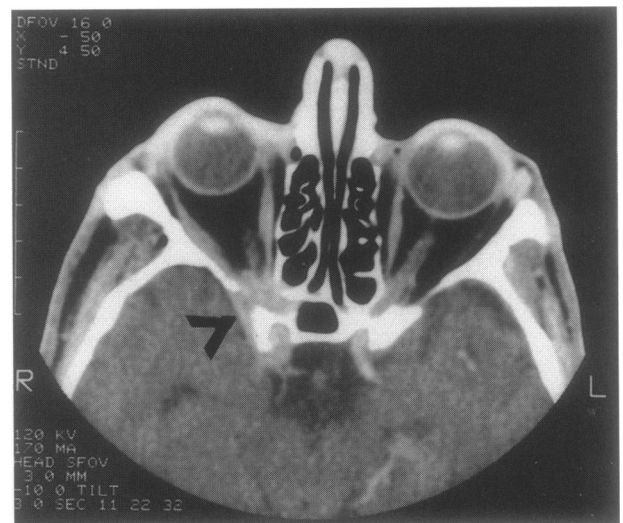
Axial CT scan of patient 4. A soft-tissue mass infiltrates the tip of the right orbital funnel (arrowhead). Deeper CT sections show that the tumor originates from the temporal bone.
